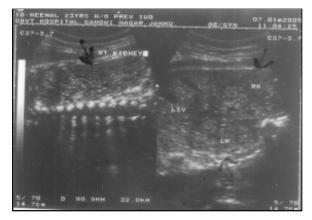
Enlarged polycystic kidneys demonstrated by fetal sonography
